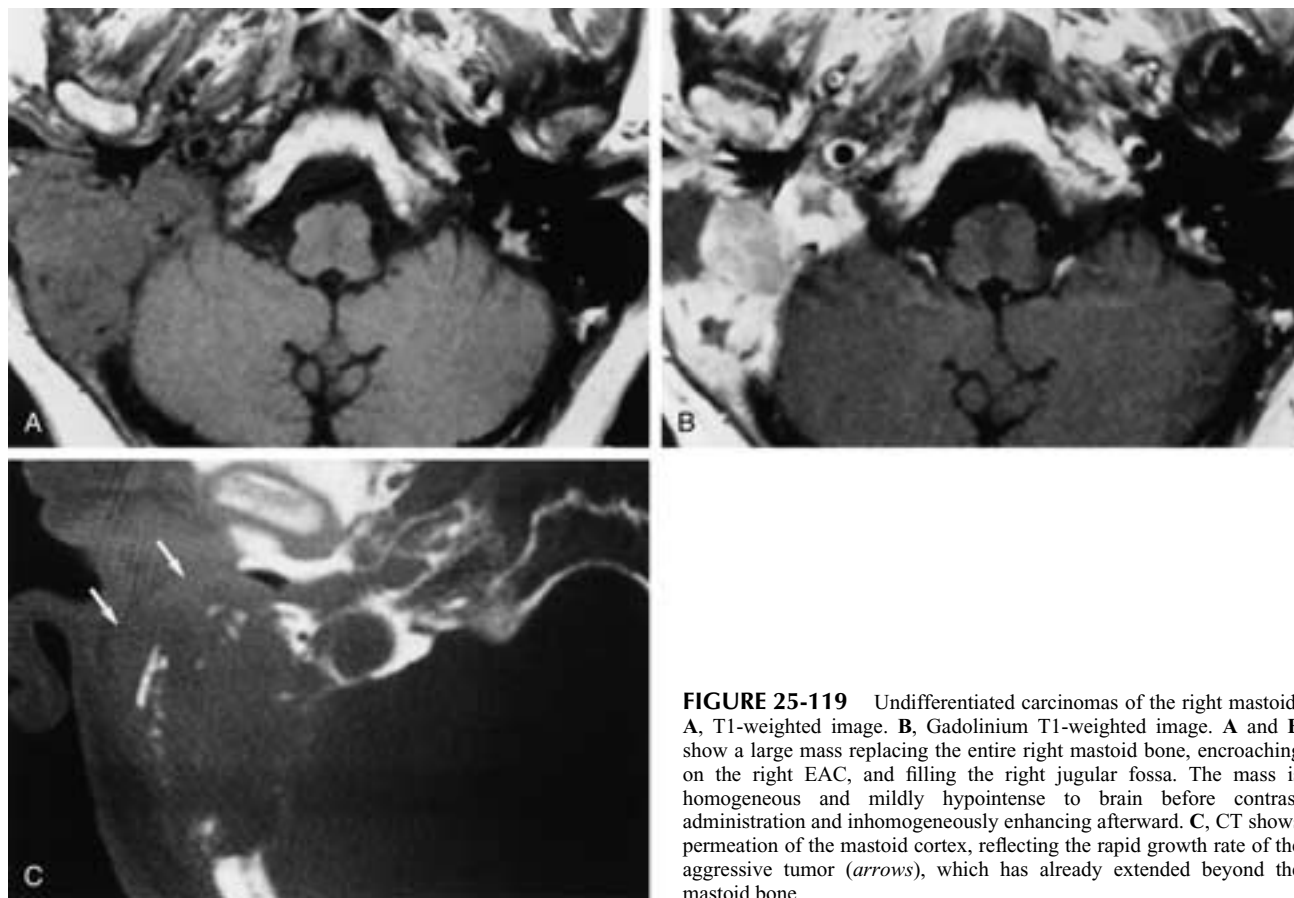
Undifferentiated carcinomas of the right mastoid. A, T1-weighted image. B, Gadolinium T1-weighted image. A and B show a large mass replacing the entire right mastoid bone, encroaching on the right EAC, and filling the right jugular fossa. The mass is homogeneous and mildly hypointense to brain before contrast administration and inhomogeneously enhancing afterward. C, CT shows permeation of the mastoid cortex, reflecting the rapid growth rate of the aggressive tumor (arrows), which has already extended beyond the mastoid bone.
